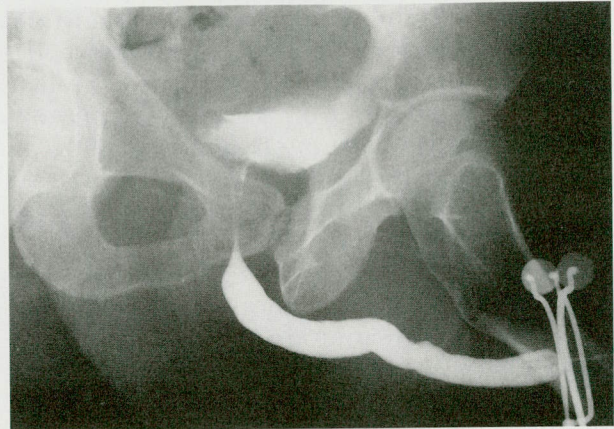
No signs of stenosis or fistulas in the radiography.
